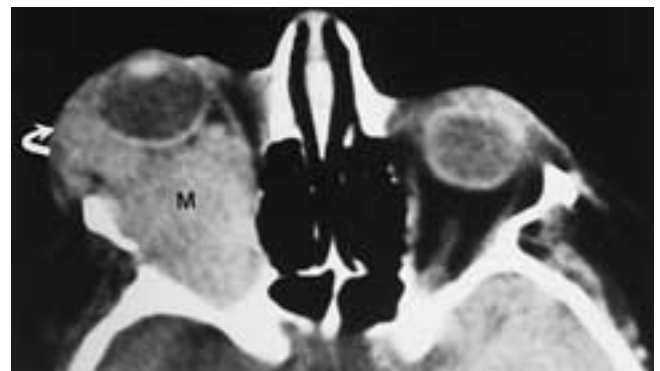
Lymphoma. Postcontrast axial CT scan shows a large mass (*M*) involving the right lacrimal gland (*arrow*) and retrobulbar region.
